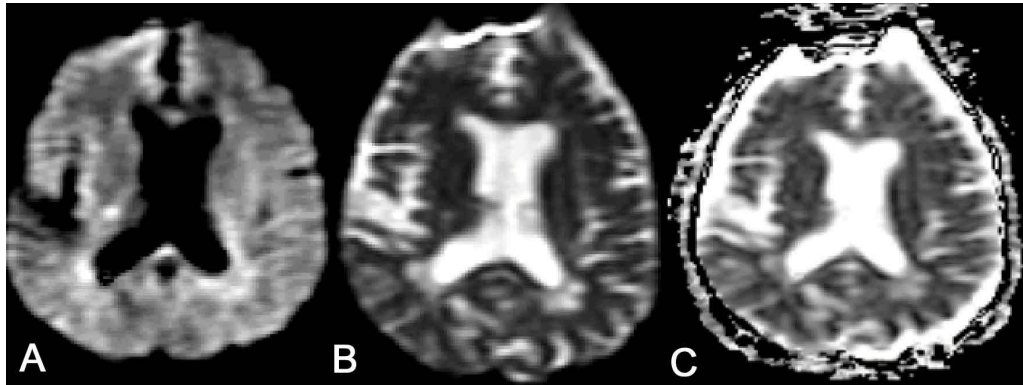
Example of MRI diffusion weighted images (DWI) from the Buffalo Neuroimaging Analysis Center in a 44 year-old man with SP MS. Echoplanar DWI is performed generating trace images with a b-factor of 1000 (a) and 0 (b) s/mm² applied in three orthogonal directions. On the b-1000 DWI map (a) lesions appear as hyperintense areas compared with the surrounding tissue most likely due to T2 shinerthrough rather than restricted diffusion. To calculate apparent diffusion coefficients (ADCs), an ADC map (c) is generated from images a and b. The diffusivity was computed separately in the x, y, and z orthogonal directions, and the results averaged to form the mean ADC map (c). Note the hyperintensity of the lesions on the ADC map (c), consistent with T2 shinerthrough.
